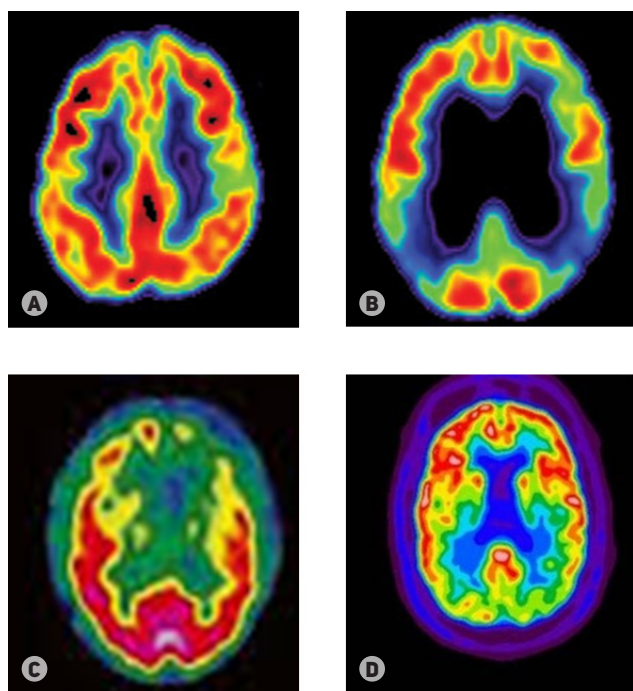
Brain perfusion SPECT with ^{99m}Tc -exametazime, axial sections. (A) Intact brain perfusion. (B) Perfusion pattern typical for Alzheimer's disease (reduced perfusion in the parietal cortex). (C) Perfusion pattern typical for frontotemporal degeneration (reduced perfusion in the frontal cortex). (D) Perfusion pattern typical for Lewy body dementia and similar to Alzheimer's; reduced perfusion is observed in the occipital cortex (Dierckx et al. [2])
